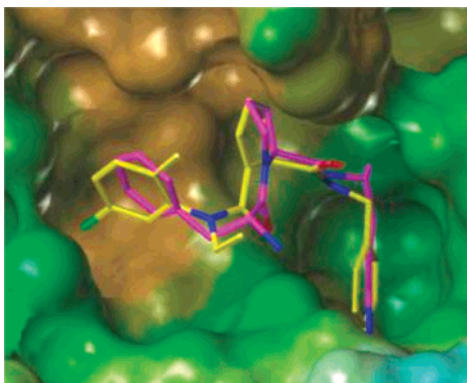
Connolly surface map of the X-ray structure of the α -thrombin-1{14} complex (yellow) at 1.9 Å resolution superimposed on the X-ray structure of the α -thrombin-PPACK complex (magenta).
